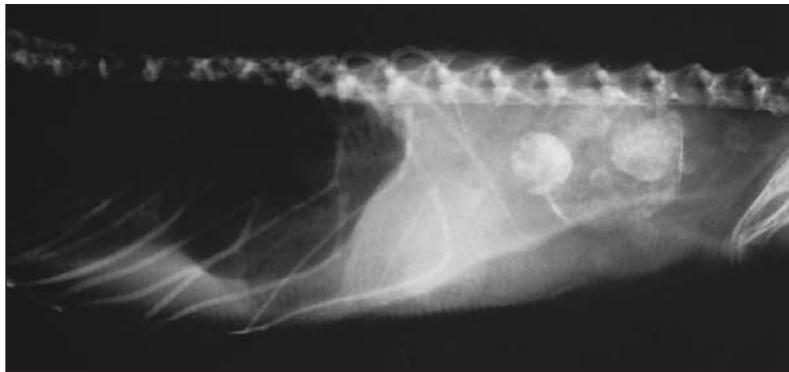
Lateral (left) and dorsoventral (right) radiographic views of a 5-year-old iguana with anorexia and signs of depression.
